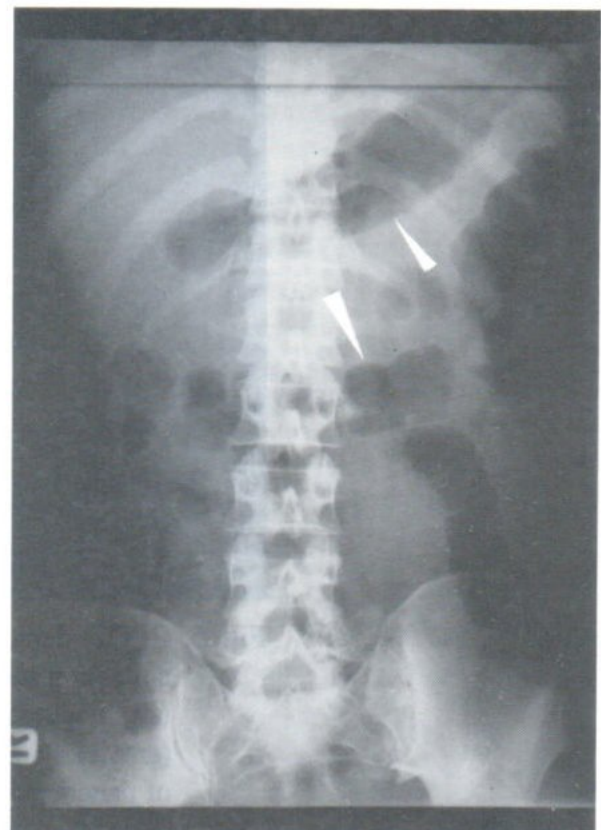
Conventional radiograph of the abdomen shows widening of gastrocolic space.
